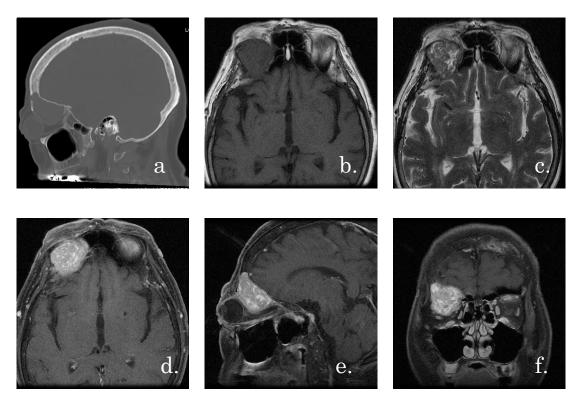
Preoperative images of a 71-year-old woman presenting with exophthalmos. (a). Computed tomography showing erosion of the frontal bone surrounding the right frontal sinus. (b), (c). Cranial magnetic resonance imaging demonstrated a right frontal sinus tumor isointense on T1- (b) and mixed iso- and hyper-intense on T2-weighted images (c). (d), (e), (f). The tumor was heterogeneously enhanced and compressed the right orbit.
